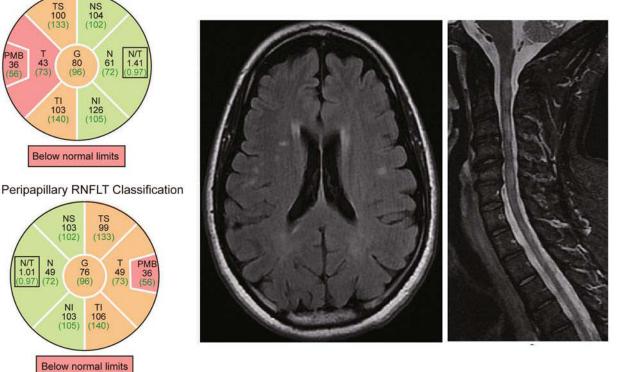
Predominant opticospinal involvement in a Caucasian woman with multiple sclerosis (MS). A Caucasian female MS patient presented with history of optic neuritis, paresthesia on upper extremities, and weakness in lower extremities. Visual evoked potential showed prolonged P100 latencies (data not shown). Left panel, pie charts depict typical features of thinned retinal nerve fiber layer (RNFL) on the right eye (OD, Oculus Dexter) and left eye (OS, Oculus Sinister). The global average (G) of the peripapillary circle scan is displayed in the center. The six standard sectors include T (temporal), TS (temporal-superior), TI (temporal-inferior), N (nasal), NS (nasal-superior), NI (nasal-inferior). PMB denotes papillomacular bundle. The black numbers display RNFL thickness for global, each sector and PMB of this woman. The green numbers in parentheses represent the values of normative database from age-matched healthy subjects. The color-coding of the pie chart depicts a specific area of "within normal limits": green; "borderline below normal": orange; and "below normal limits": red. The color-coding bar below each pie chart indicates the overall classification. Middle, brain MRI showed minimal white matter lesions. Right, cervical spine MRI, however, demonstrated a large burden of MS lesions.
